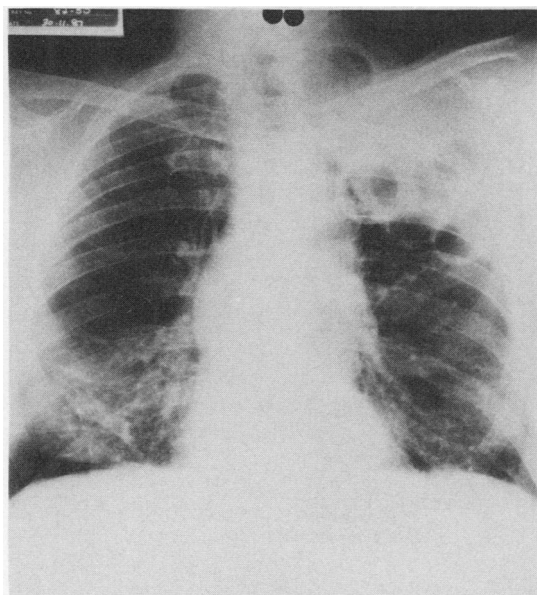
Case 3: Chest radiograph 30 years after a left limited thoracoplasty and lucite sphere plombage. Examination of serial films over the years suggested that the sphere seen at the upper right had gradually altered its position.*
